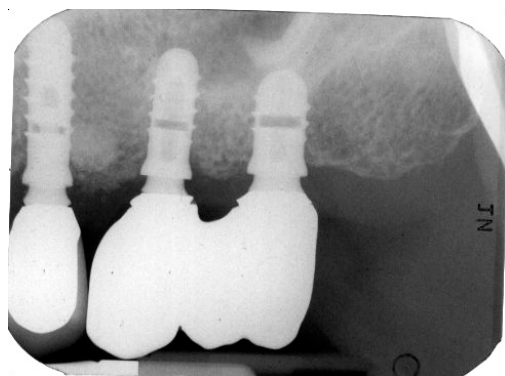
X-ray after the implant retrieval and rehabilitation restoration.
